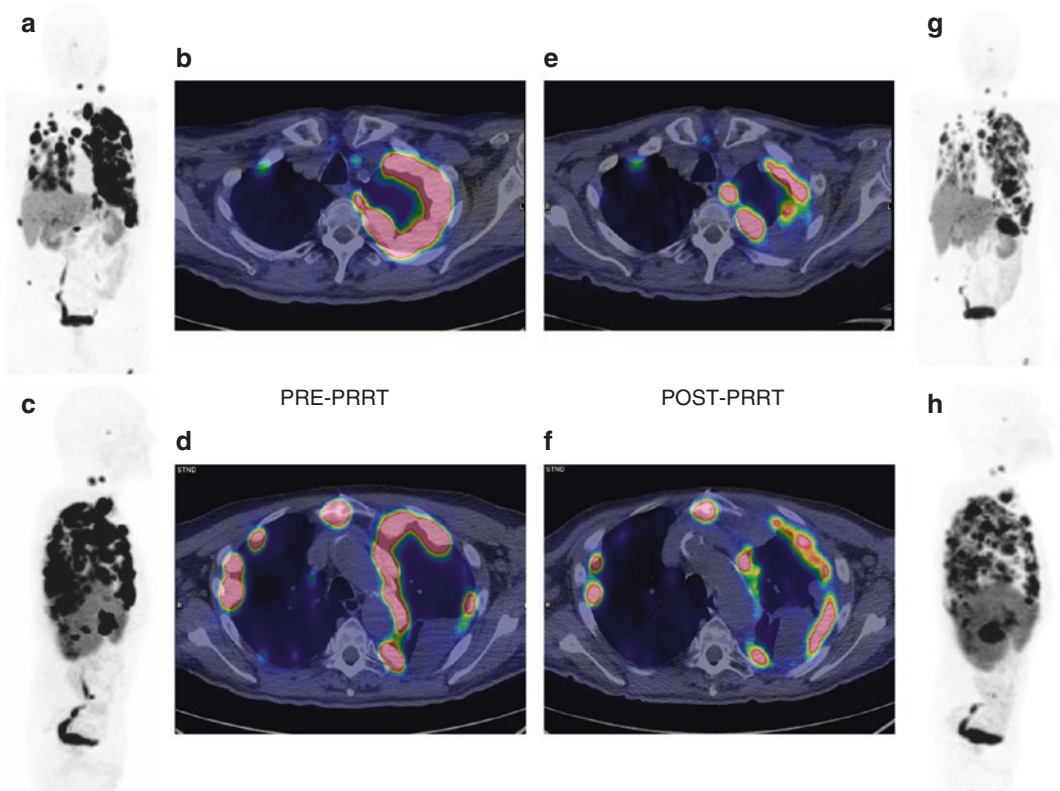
Patient with a thyroid Hurthle cell carcinoma. ^{68}Ga -DOTATOC PET/CT at baseline (a–d) shows multiple sites of disease in the thyroid bed, lymph nodes, lungs, and bone. The patient underwent six cycles of ^{90}Y -DOTATOC (total activity: 11.7 GBq). At
